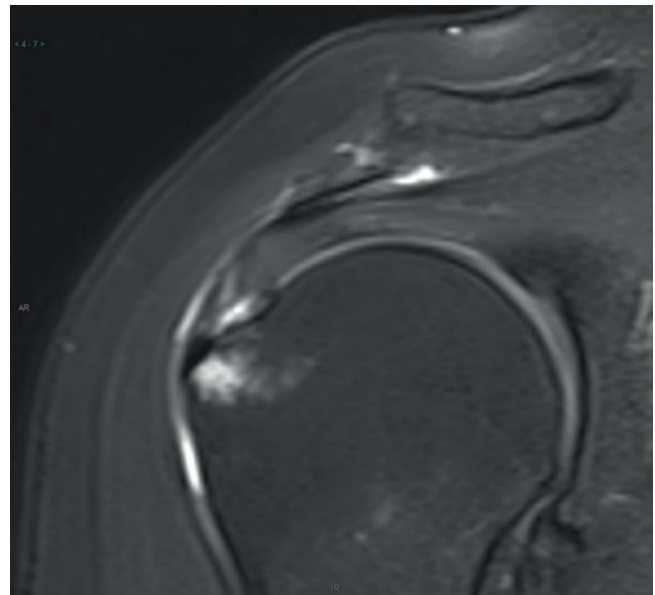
Coronal oblique T2-weighted fat suppressed image showing partial thickness intrastance tear at the footprint, with adjacent bone marrow edema, tendinosis and bursitis
